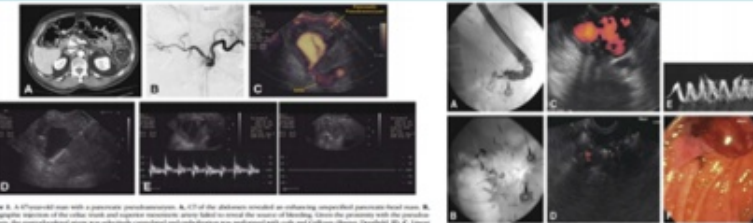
A 70-year-old man with a pancreatic pseudocyst. A, CT of the abdomen revealed an enhancing, unseptated pancreatic fluid mass. B, Sonographic depiction of the cystic fluid and superior mesenteric artery failed to reveal the source of bleeding. C, Close proximity with the pancreatic system. The gastroduodenal artery was selectively cannulated and embolization was performed with coils and Lethalium (Boston, Duxbury, MA). D, Linear EUS and power Doppler revealed the exact point of communication between the gastroduodenal and superior mesenteric arteries. E, A 1.5-cm-long piece of wire inserted into the pseudocyst and advanced to the site of the feeding vessel, where 7 mL of 95% alcohol was injected. F, A post-embolization Doppler image on the left demonstrates a clear flow area initially, the image on the right was taken 20 minutes later and shows that blood flow within the pseudoaneurysm completely ceased.
